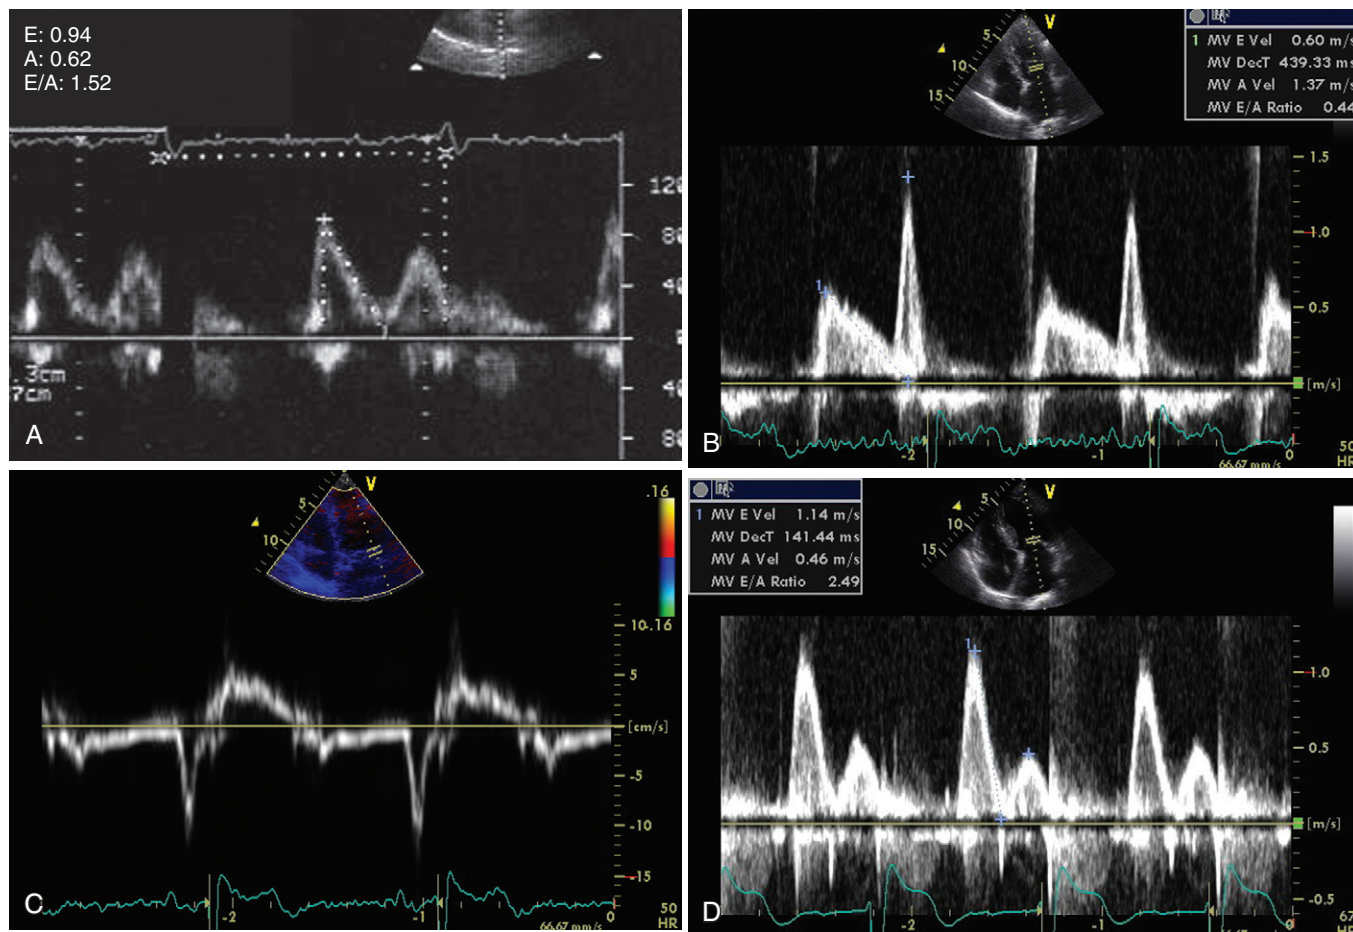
A, Example of a normal Doppler mitral profile. The E wave is 94 cm/sec, deceleration time (DT) is 174 msec, and E/A ratio is 1.0. B, Mitral flow velocity recording shows abnormal relaxation. The E/A ratio is 0.44 and DT is prolonged (439 msec). C, DTI of the mitral annulus at the lateral level, depicting inversion of the normal pattern, with $E' < A'$. D, Restrictive mitral valve flow pattern with short DT (141 msec) and E/A of 2.5.
